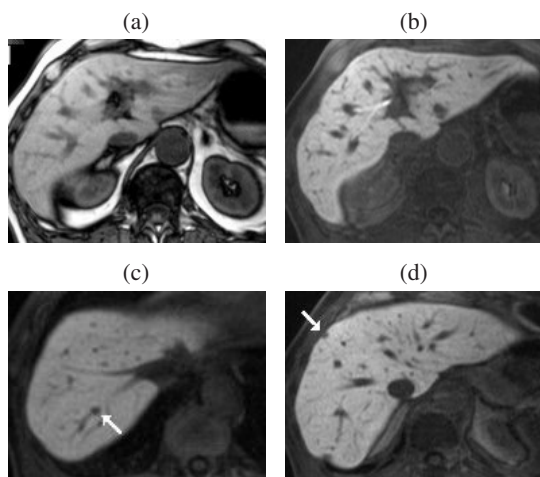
Multiple metastases—improved detection with Gd-EOB-DTPA at the hepatocyte phase of enhancement. Compared with non-contrast T1w images (a) liver-to-lesion contrast is improved on 20 min post-contrast T1w images (b). Additional surgically confirmed sub-cm lesions (arrows) were only visible on hepatocyte phase images ((c) and (d)). Adapted with permission from Robinson PJA, Ward J (2006) *MRI of the Liver: A Practical Guide*. Informa Healthcare, New York.
